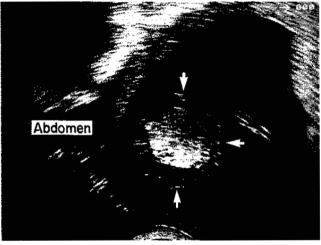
Transvaginal ultrasound scan of 11-week fetus showing marked oedema of scalp and abdominal wall (arrows). The karyotype was 45 XO (Turner syndrome).
